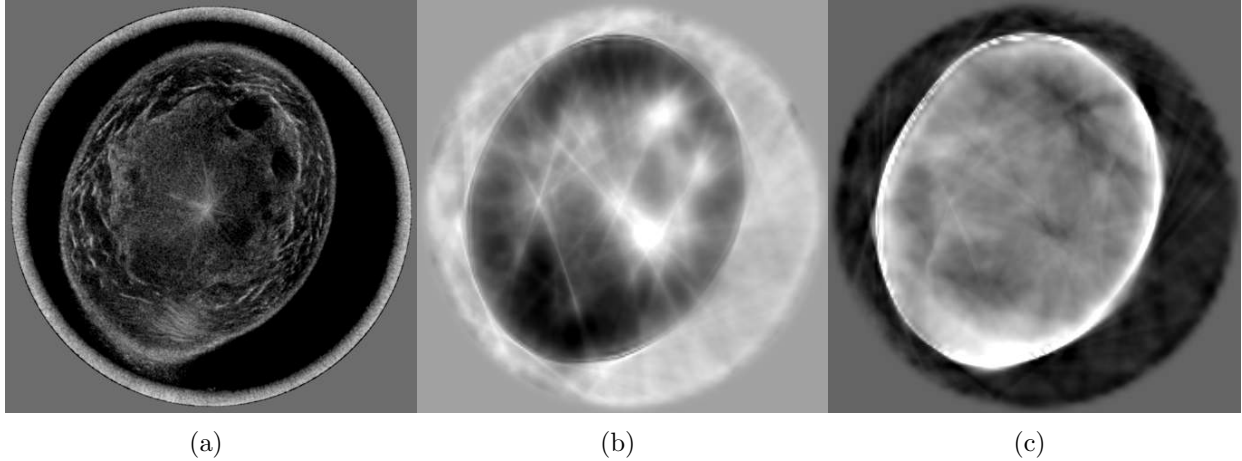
Ultrasound Tomography Scan of Small Benign Cysts in a Dense Breast. (a) Reflection. (b) Sound speed (m/s). (c) Attenuation (dB/mm).
